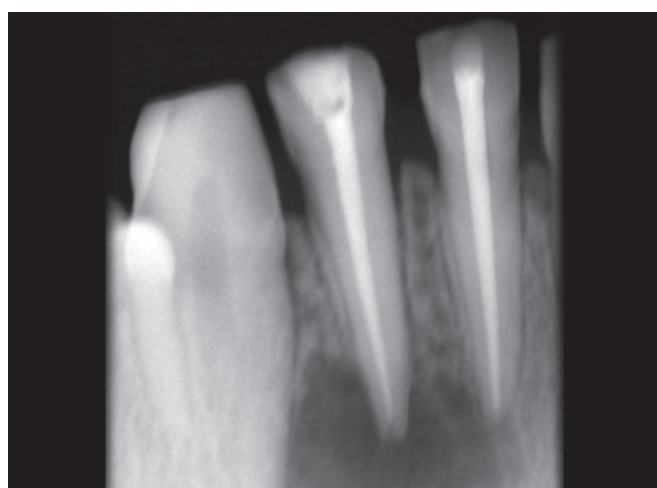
Obturation radiograph (Case 2)
